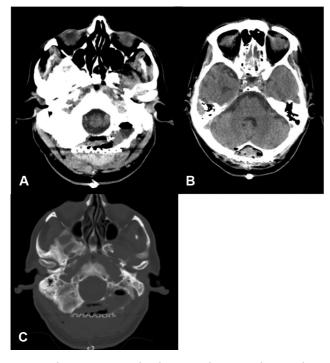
1-day postoperative head computed tomography scan showing no major complications. In the bone window, we can observe the correct placement of the cranioplasty titanium mesh.
